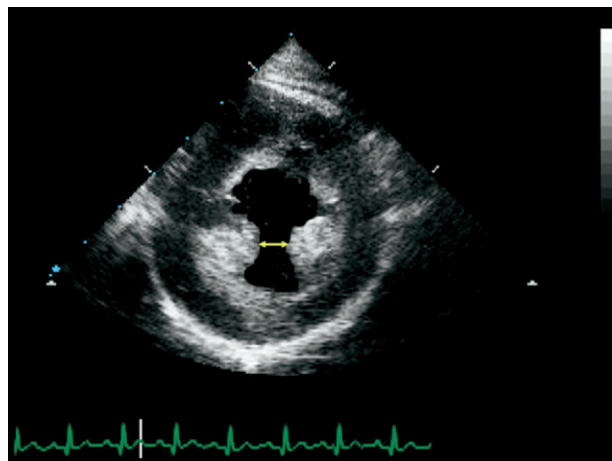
Interpapillary muscle distance is measured as the empty distance between the two papillary muscles (arrow) at end systole on transthoracic echocardiography.
